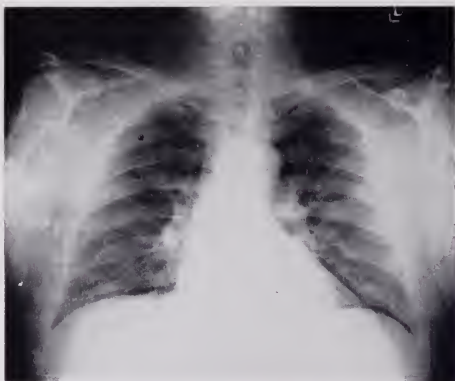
Roentgenogram of the chest, showing the usual relationship of the left and right leaves of the diaphragm.
